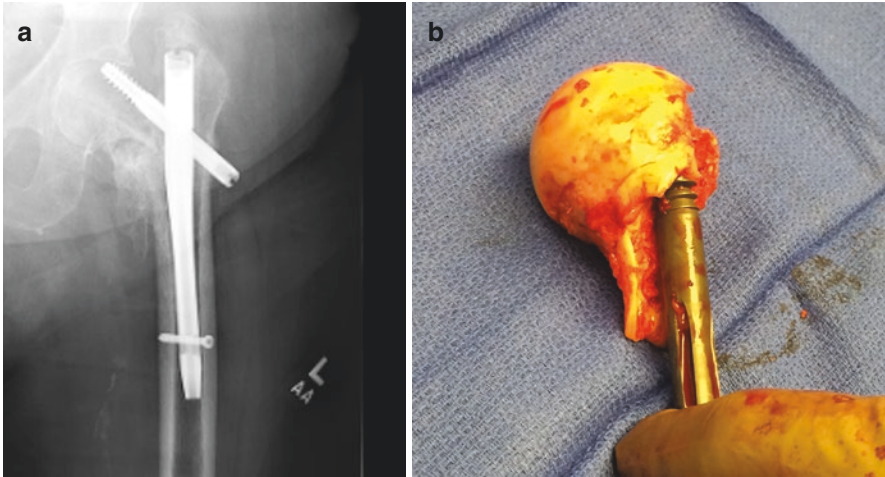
(a) AP radiograph of a left hip demonstrating superior lag screw cut-out following treatment of a pertrochanteric hip fracture with a short cephalomedullary nail. (b) Clinical demonstration of the superior lag screw cut-out in this patient
